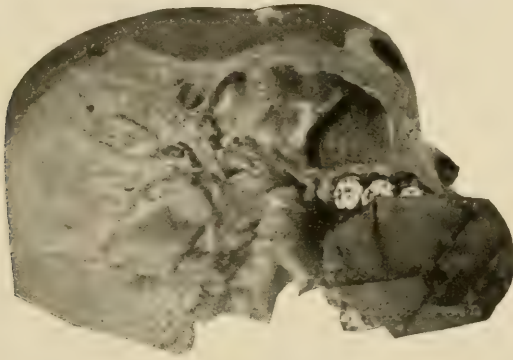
Position of the film in the mouth for pose and radiograph seen in Fig. 96.
